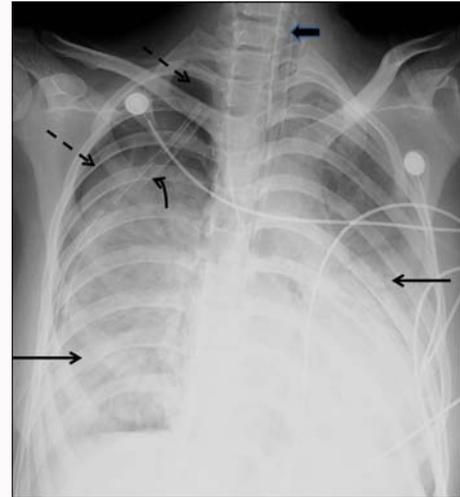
AP chest radiograph of 20-year-old female showing diffuse consolidation bilateral lung fields (black arrow) with a right sided pneumothorax devoid of bronchovascular markings (dashed arrow) with chest tube *in situ* (curved arrow). Also note the endotracheal tube *in situ* (block arrow).
